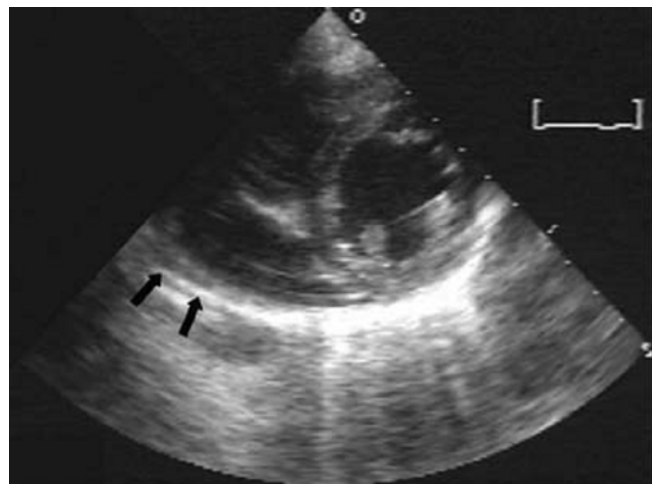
On the parasternal short-axis view, echocardiography showed diffuse pericardial effusion (arrows) with diastolic collapse of the right ventricular wall.
